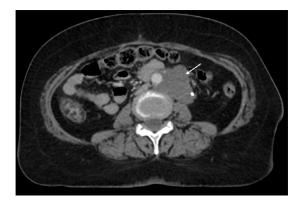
The follow-up CT scan showed interval regression in the size of the mass.
